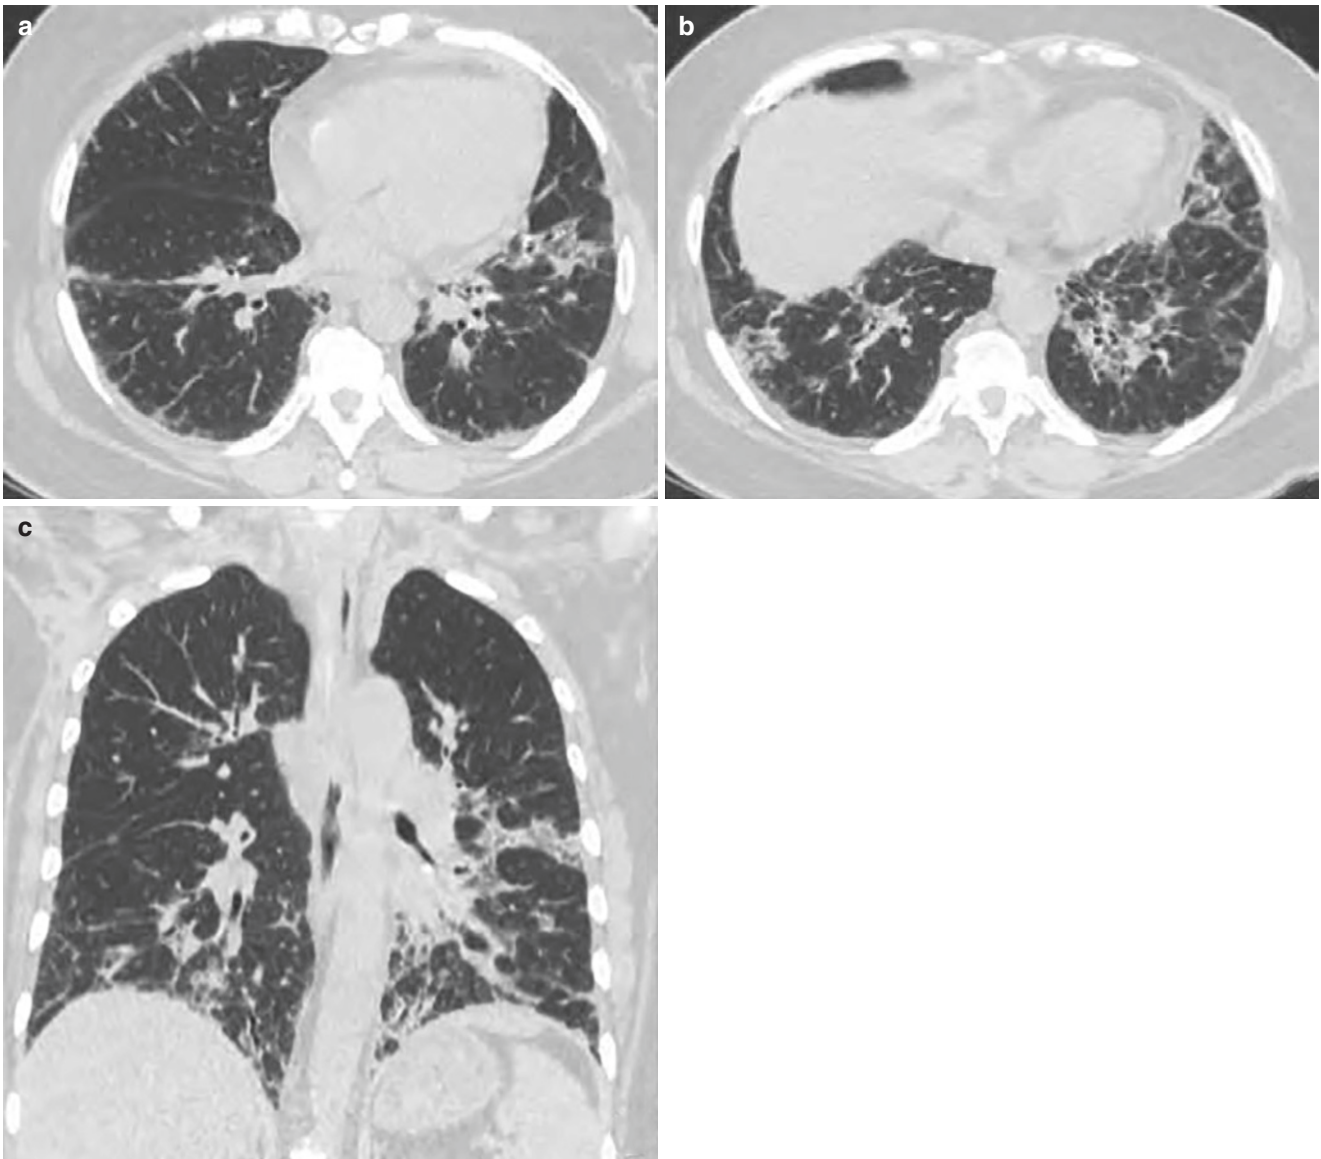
Nonspecific interstitial pneumonia caused by nitrofurantoin. (a–c) CT lung window showed multiple thickened interlobular septa and reticular opacities, accompanied by patchy ground-glass opacities under the pleura of both lower lobes of the lungs
